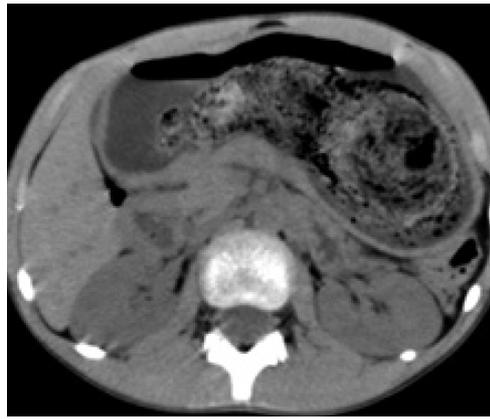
Axial computed tomography image showing a hairball in the stomach.
